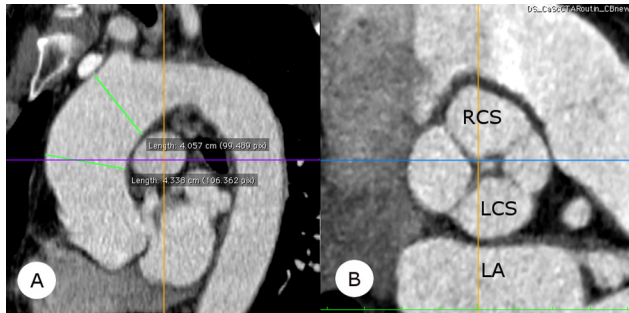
Panel A. Computed tomographic (CT) angiography of moderately dilated ascending aorta. Panel B. CT angiography of Type B quadricuspid aortic valve (QAV). LA = left atrium; LCS = left coronary sinus; RCS = right coronary sinus.
